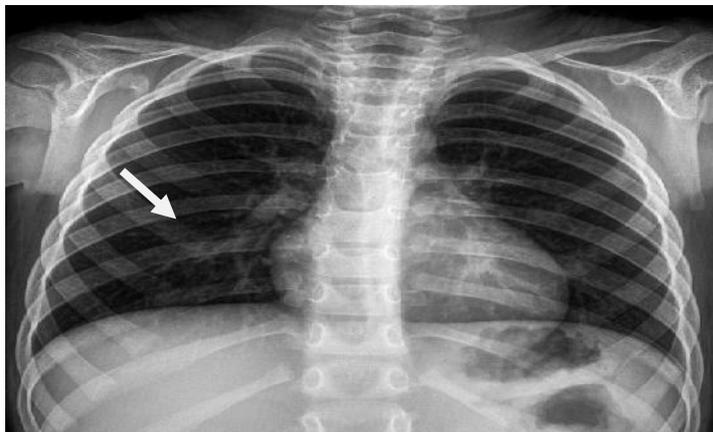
Plain chest x-ray (antero-posterior view) showing perihilar densities with increased bronchovascular markings at the right side.
